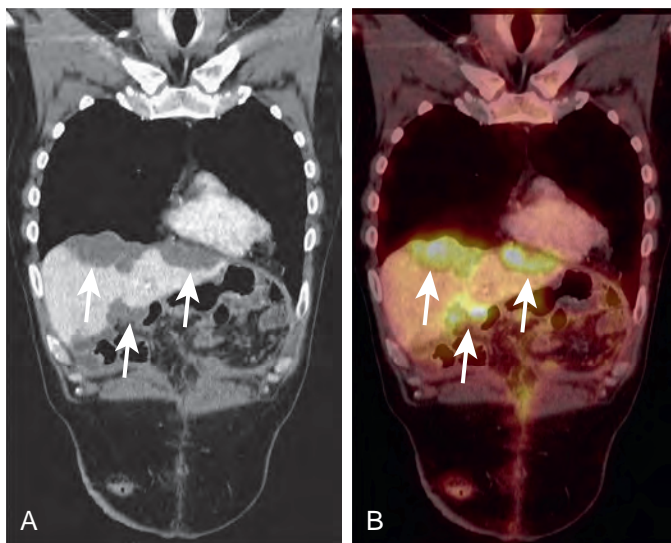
Metastatic colon cancer. A. Coronal contrast-enhanced CT scan demonstrates multiple, low-density peritoneal implants (arrows) along the surface of the liver in this patient with known mucinous adenocarcinoma of the colon. B. Corresponding coronal fused PET/CT shows intense FDG uptake in the peritoneal deposits (arrows). Mucinous tumors have variable and frequently low FDG uptake. However, in this patient, the metastases had intense FDG uptake.
